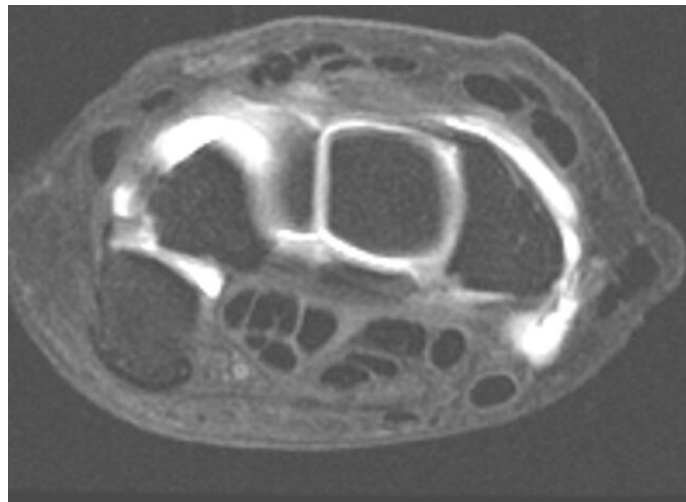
T2-weighted magnetic resonance imaging of a case of post-traumatic PTJ osteoarthritis due to PTJ instability with rupture of the pisohamate ligament (ulnar deviation of the pisiform)
